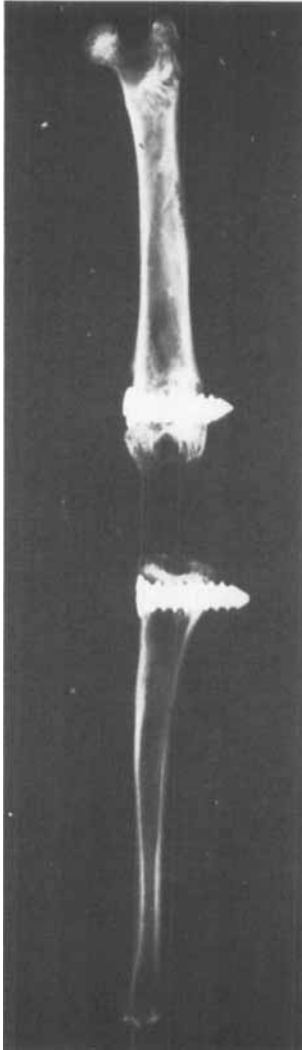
X-ray of dissected femur and tibia at 6 weeks after the insertion of the screws.
